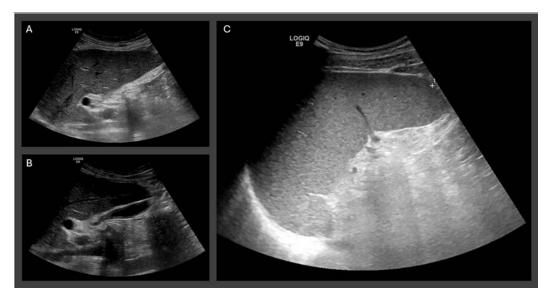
Abdominal ultrasound assessment of the liver and spleen. Abdominal ultrasound scan showing the liver parenchyma. Image A shows mildly increased echogenicity suggestive of fatty liver disease. Image B shows normal diameter of the biliary tree with no evidence of gallstones. Image C is an ultrasound image of an enlarged spleen.
